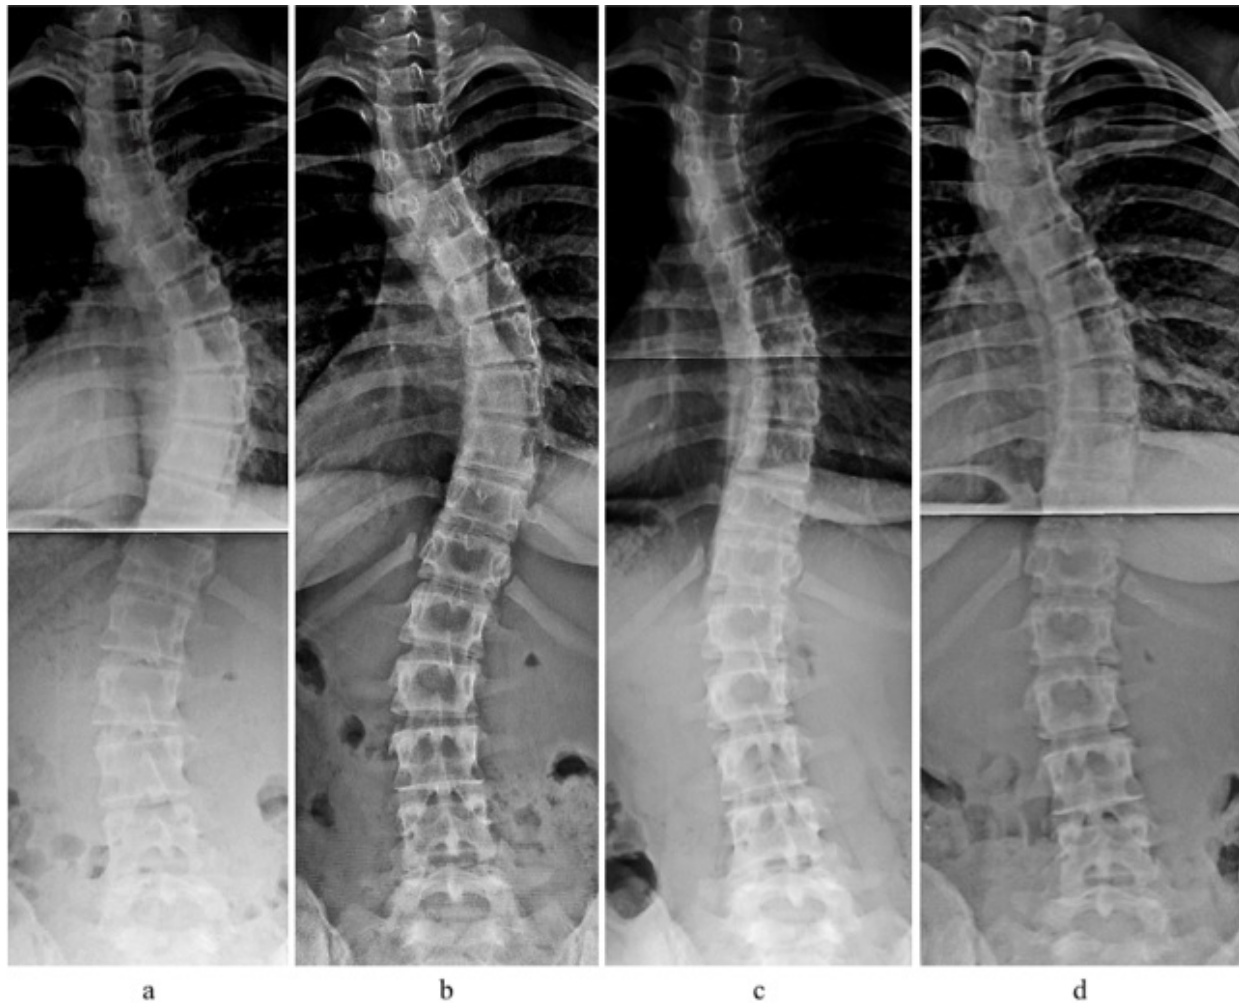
a) February 2016, b) April 2016, c) October 2016, d) April 2017. X-ray b is the patient's initial x-ray prior to beginning her PSSR program. X-ray d was taken one year later. The patient's x-rays were performed at one of two local hospitals in the metropolitan Boston area.
